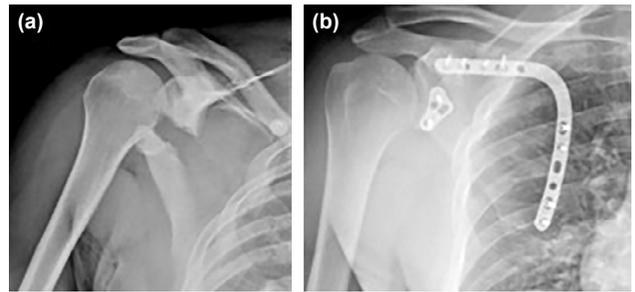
47-year-old male patient with right scapula Ideberg Type 4 fracture (a) pre-operative shoulder X-ray (b) post-operative antero-posterior shoulder X-ray.
